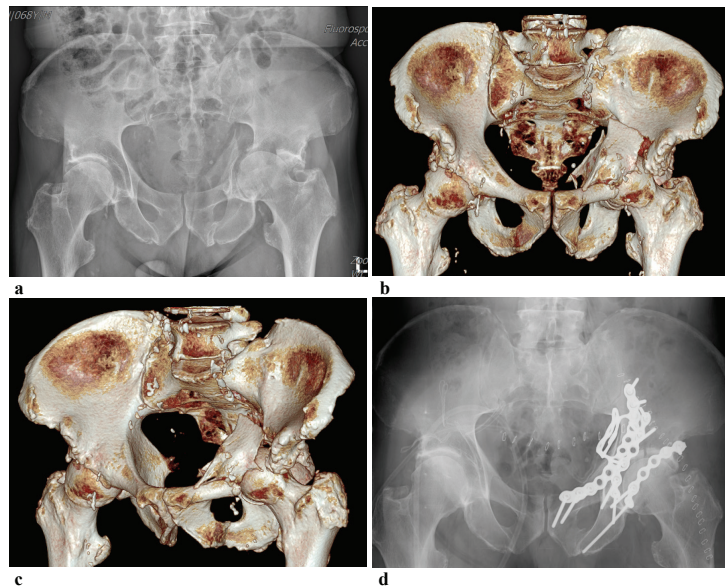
(a) Preoperative pelvis x-ray; (b, c) preoperative computed tomography scan; (d) postoperative pelvis x-ray.
